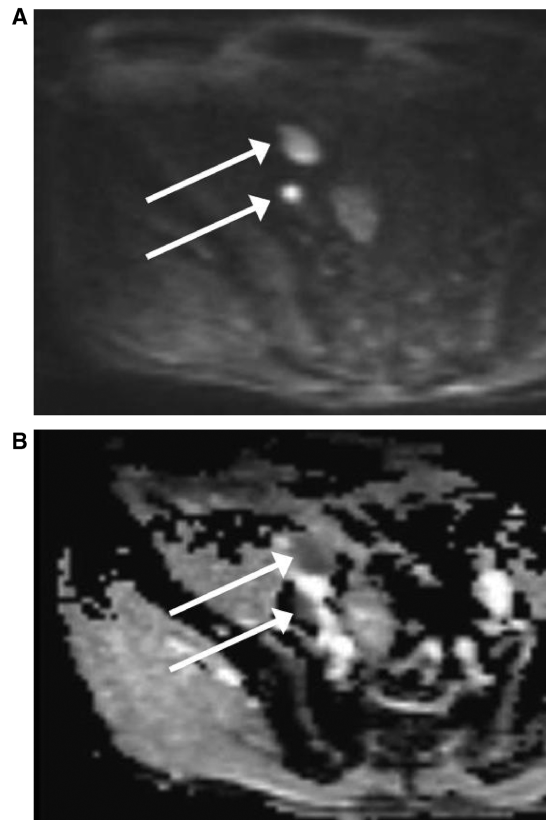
MRI (at 3 T) of a 50-year-old patient with 2 lymph node metastases from prostate carcinoma in the right external iliac chain. (A) On the DW-MR image at a b value of 1000 s/mm^2 the lymph node metastases show high signal intensity (arrows). (B) On the corresponding ADC map the lymph node metastases reveal impeded diffusion, represented by colour shades of dark grey.
